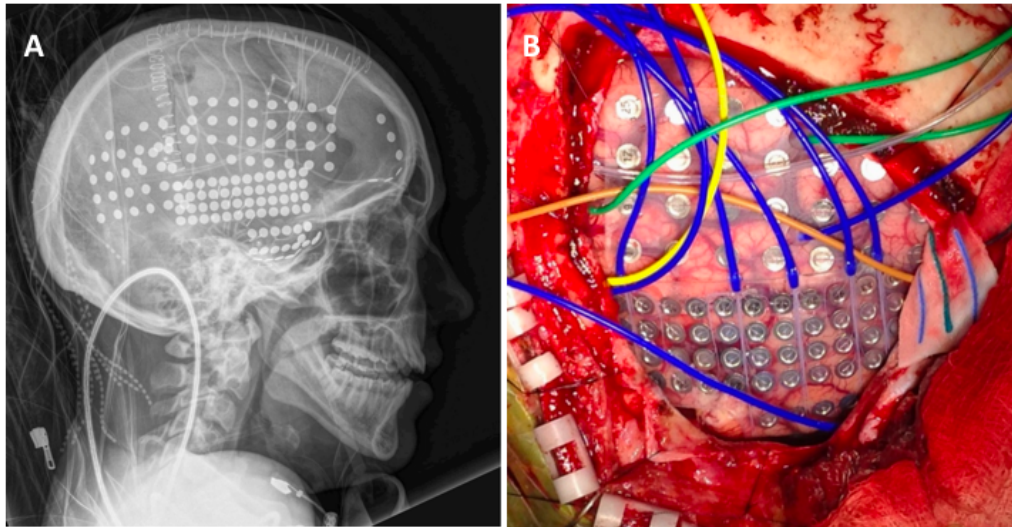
A) X-ray scan that reveals the grid on the skull B) Implanted grid on cortex
